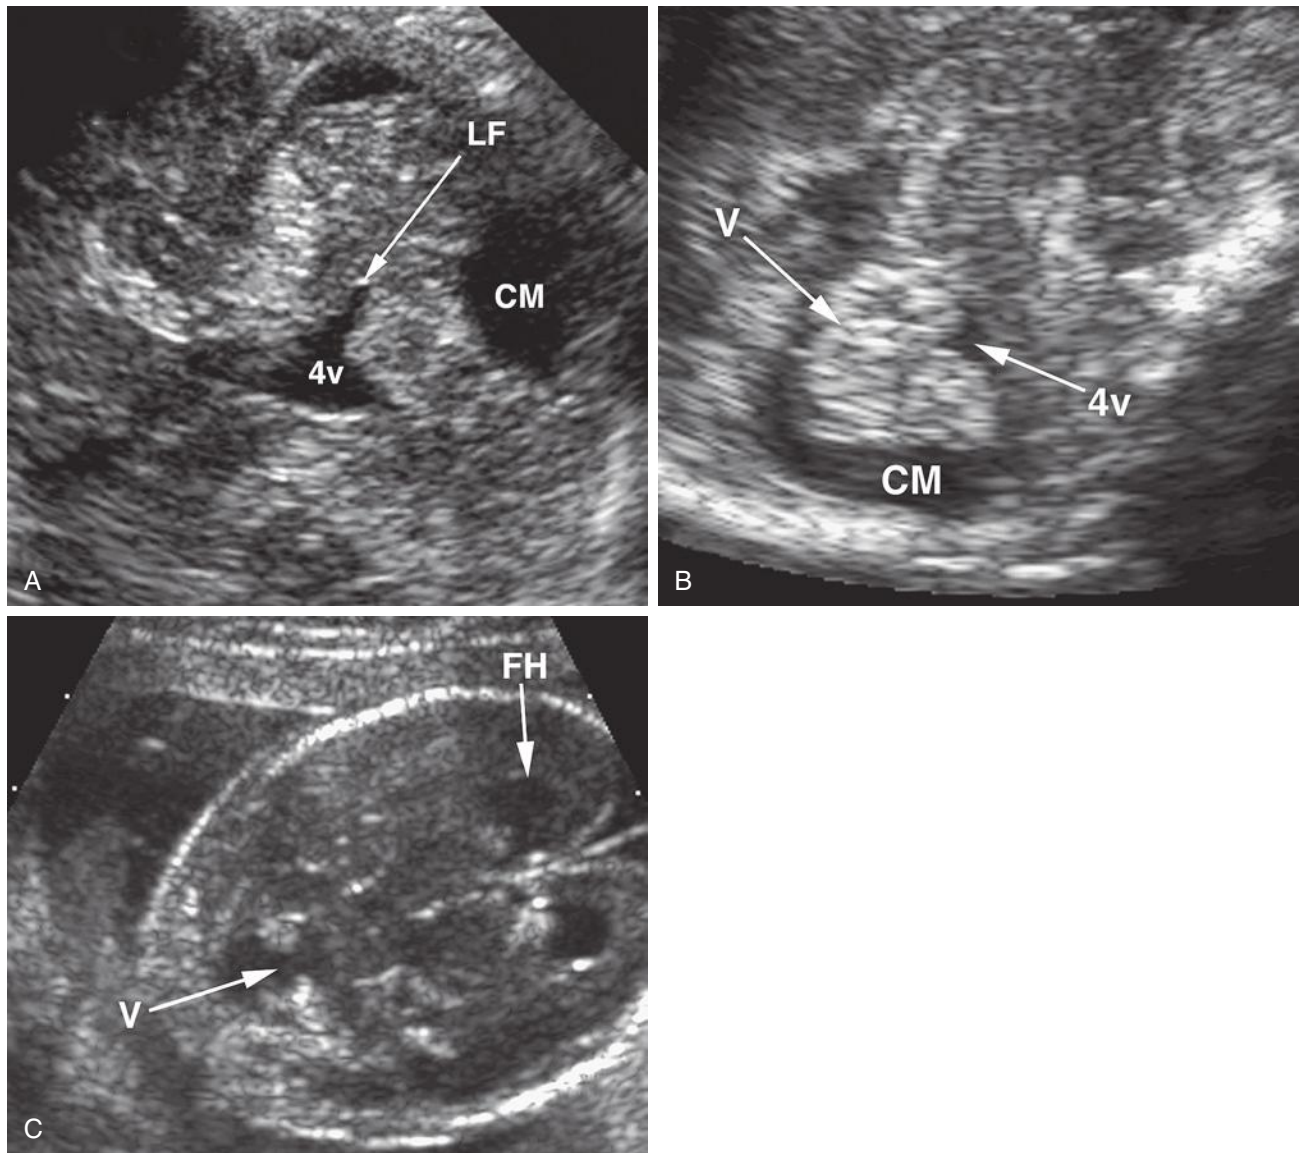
Three images of the posterior fossa at different stages of cerebellar development. A and B are images of later fetuses whereas C is obtained in the early second trimester. A, Transverse axial sonogram of the posterior fossa demonstrating the fourth ventricle (4v) and the Luschka foramen (LF). Lying between the fourth ventricle and the cisterna magna (CM) is the fully developed inferior vermis. B, Parasagittal sonogram of the posterior fossa. The fully developed vermis (V) is seen. The fourth ventricle is outlined by the superior peduncle and ala lobula centralis superiorly and the nodule and tonsil inferiorly. The inferior vermis is well depicted between the fourth ventricle and cisterna magna (CM). Note that the vermis appears very brightly echogenic because of the large number of folia and, most importantly, the intervening leptomeninges covering the surfaces of the folia. C, Transverse axial sonogram of the posterior fossa demonstrating the fourth ventricle communicating freely with the cisterna magna across an incompletely formed inferior vermis (V). This is a normal finding at this early stage of pregnancy. FH, frontal horn.
